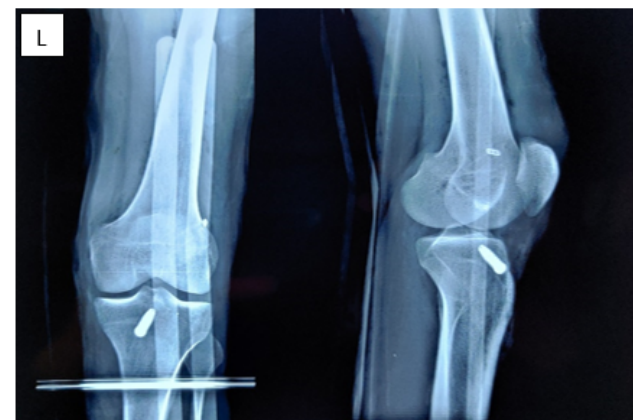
Post-op X-ray showing reconstructed ACL with endobutton and interference screw
